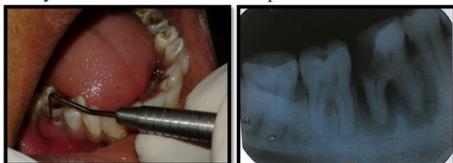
clinical and radiographic picture of endoperio lesion
